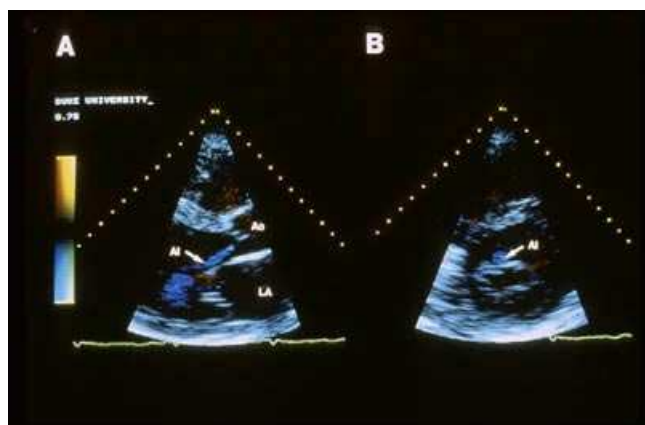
28 Left parasternal long-axis view of aortic insufficiency filling the entirety of the left ventricular outflow tract in diastole. A variance map was used.
